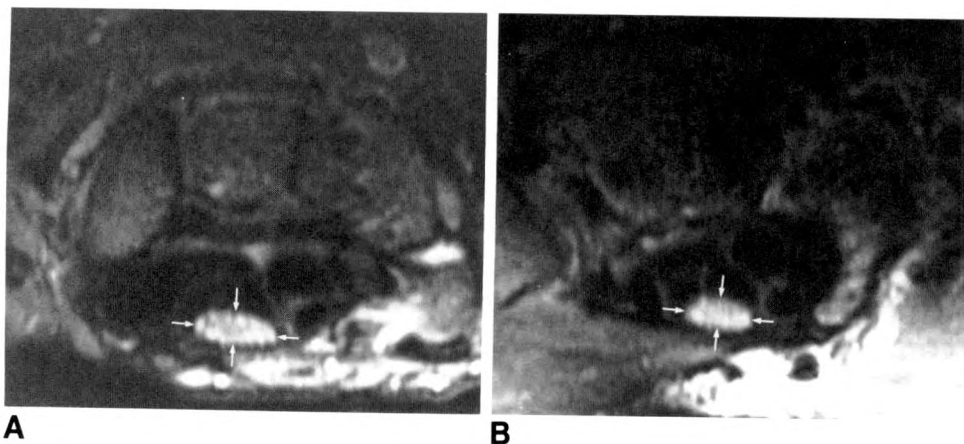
Diffuse swelling of median nerve (arrows). Axial MR images (TR 2000, TE 60) of left wrist viewed toward elbow with palm down in patient with bilateral postpartum carpal tunnel syndrome. Note enlargement as well as markedly increased signal intensity at both level of pisiform (A) and level of hook of hamate (B). Right wrist had similar appearance.
